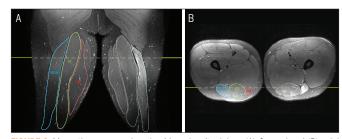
Magnetic resonance imaging 14 weeks after injury. (A) Coronal and (B) axial T2-weighted images of the thighs demonstrating a diffuse increase in signal (increased brightness) throughout the entirety of the left BFLH muscle and a portion of the ST, most consistent with subacute denervation edema. The yellow lines represent the locations of coronal and axial slices. Abbreviations: BFLH, biceps femoris long head; SM, semimembranosus; ST, semitendinosus.
